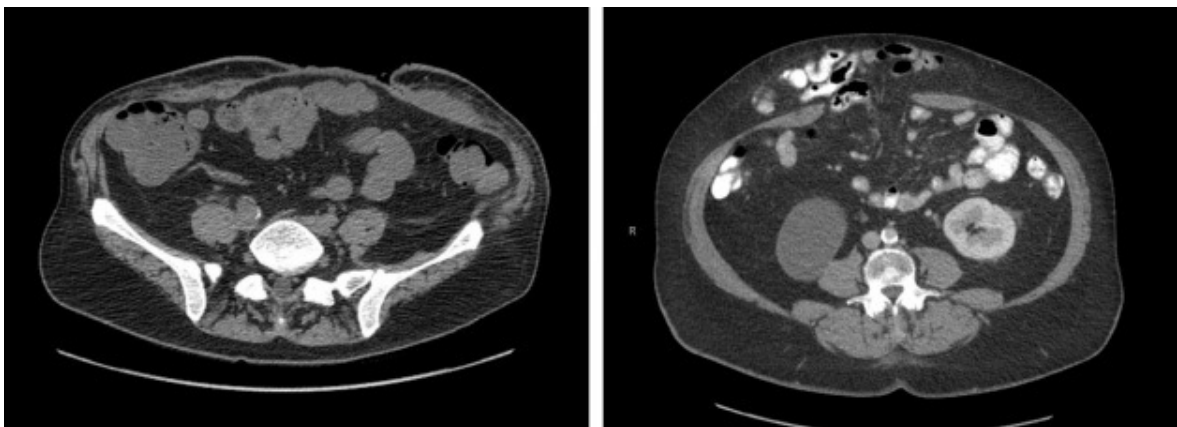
• Computed tomography images from a patient with an open abdomen and associated lateral
